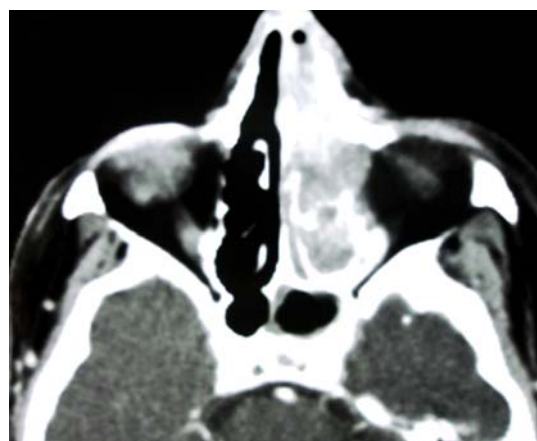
Axial computed tomography (CT) image showed an enhancing mass invading the left ethmoid sinus.
